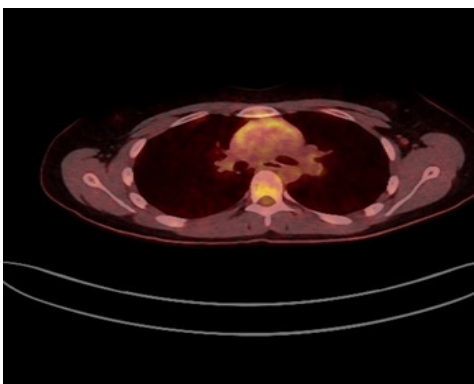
Cardiac Sarcoidosis- PET/CT scan showing patchy hypermetabolism of FDG in a pattern consistent with cardiac sarcoidosis.
